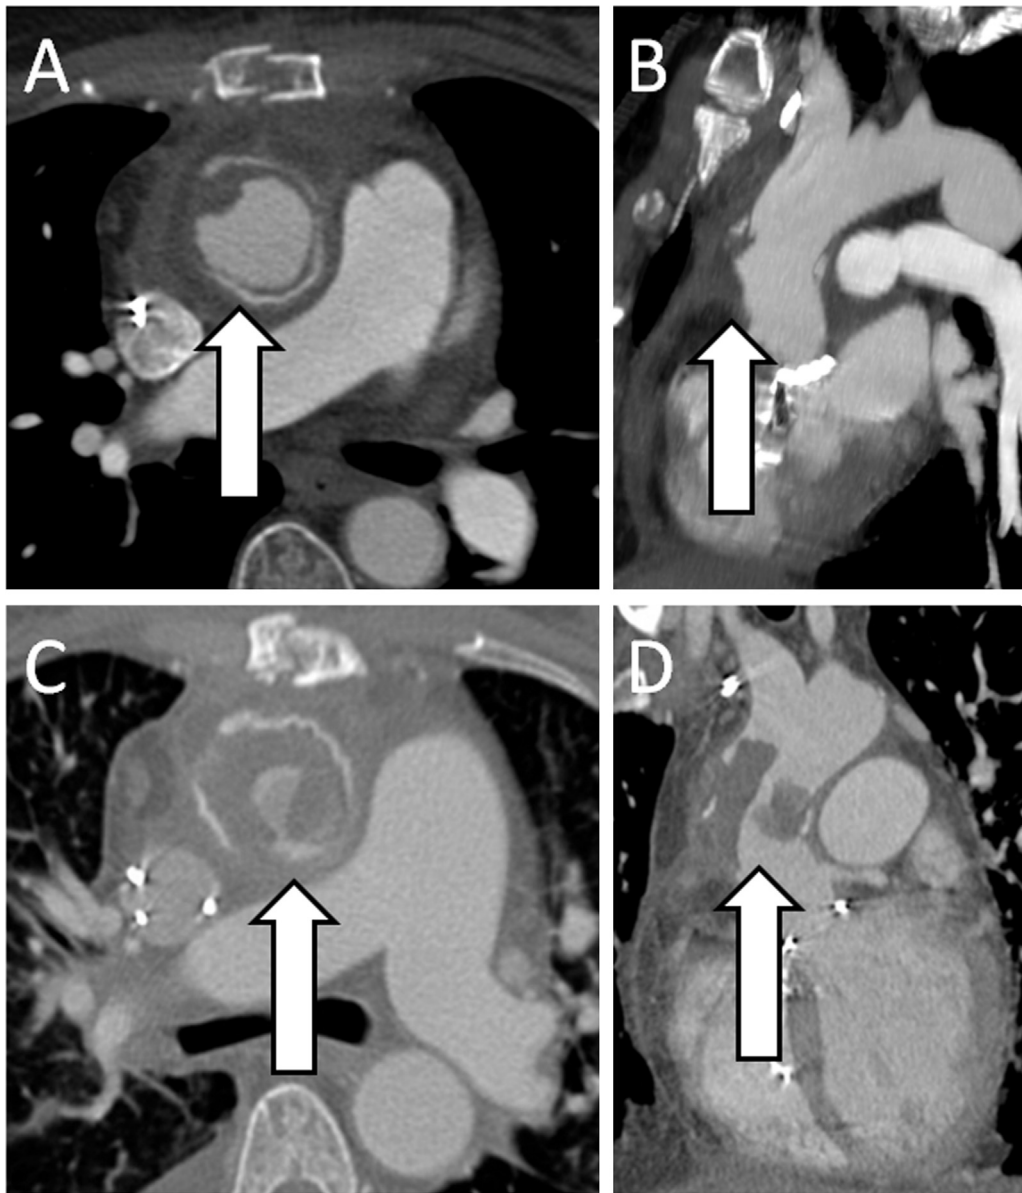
Sixty-four-slice contrast-enhanced computed tomography angiography (CTA) of the chest done 2 months prior to admission to rule out pulmonary embolism (A and B), and on this admission (C and D). The previous CT findings (arrows) were interpreted as postsurgical changes with a nonspecific rim of fluid in the aortic graft. Repeat CT on this admission demonstrated a large filling defect (arrows) within the Dacron aortic root graft. (A and C: axial views; B and D: sagittal views.).
